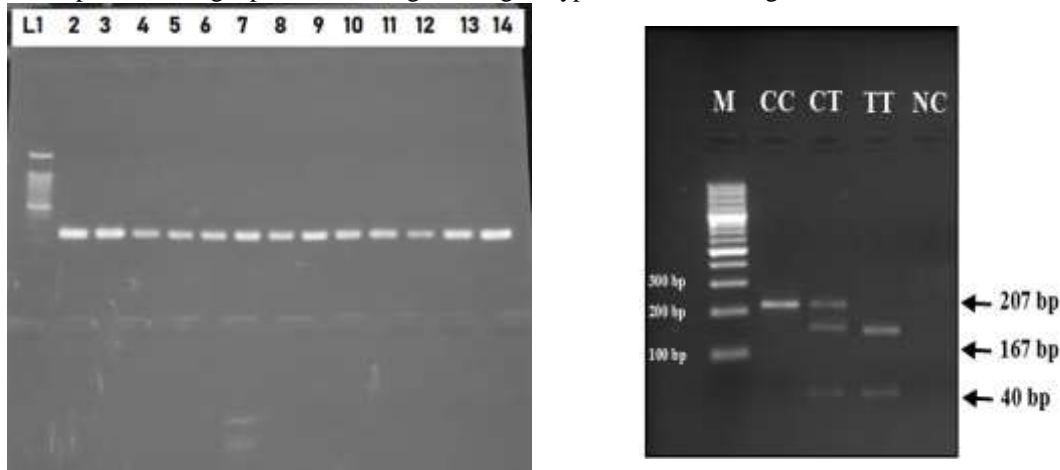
Representative gel showing SOD2 -C-47-T genotypes. Lane 1 100bp DNA ladder (Marker, M), Lane 2 CC UD Undigested (207bp), Lanes 3 CT (207, 167 & 40 bp), Lane 4 TT (167 & 40 bp).
